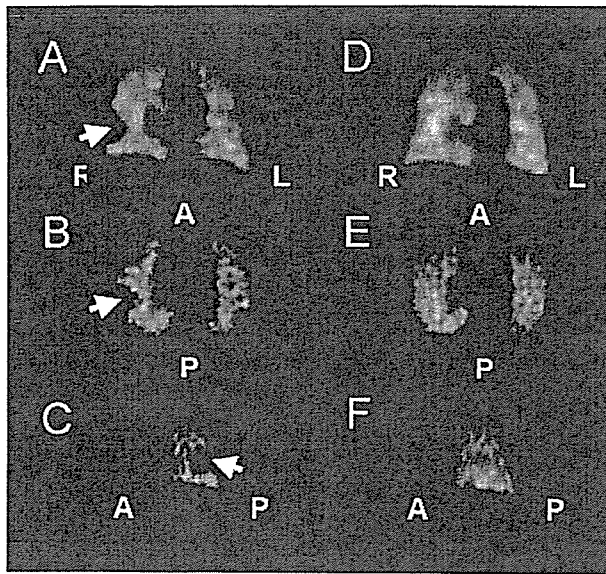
Baseline SPECT (A–C) and posttreatment SPECT (D–F) in a patient with preoperative pulmonary embolism. Defects are marked by arrows. SPECT, single-photon emission computed tomography; R, right; L, left; A, anterior; P, posterior
